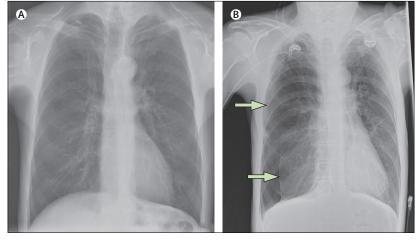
Chest radiographs of a patient with chronic obstructive pulmonary disease before (A) and after (B) pneumothorax
